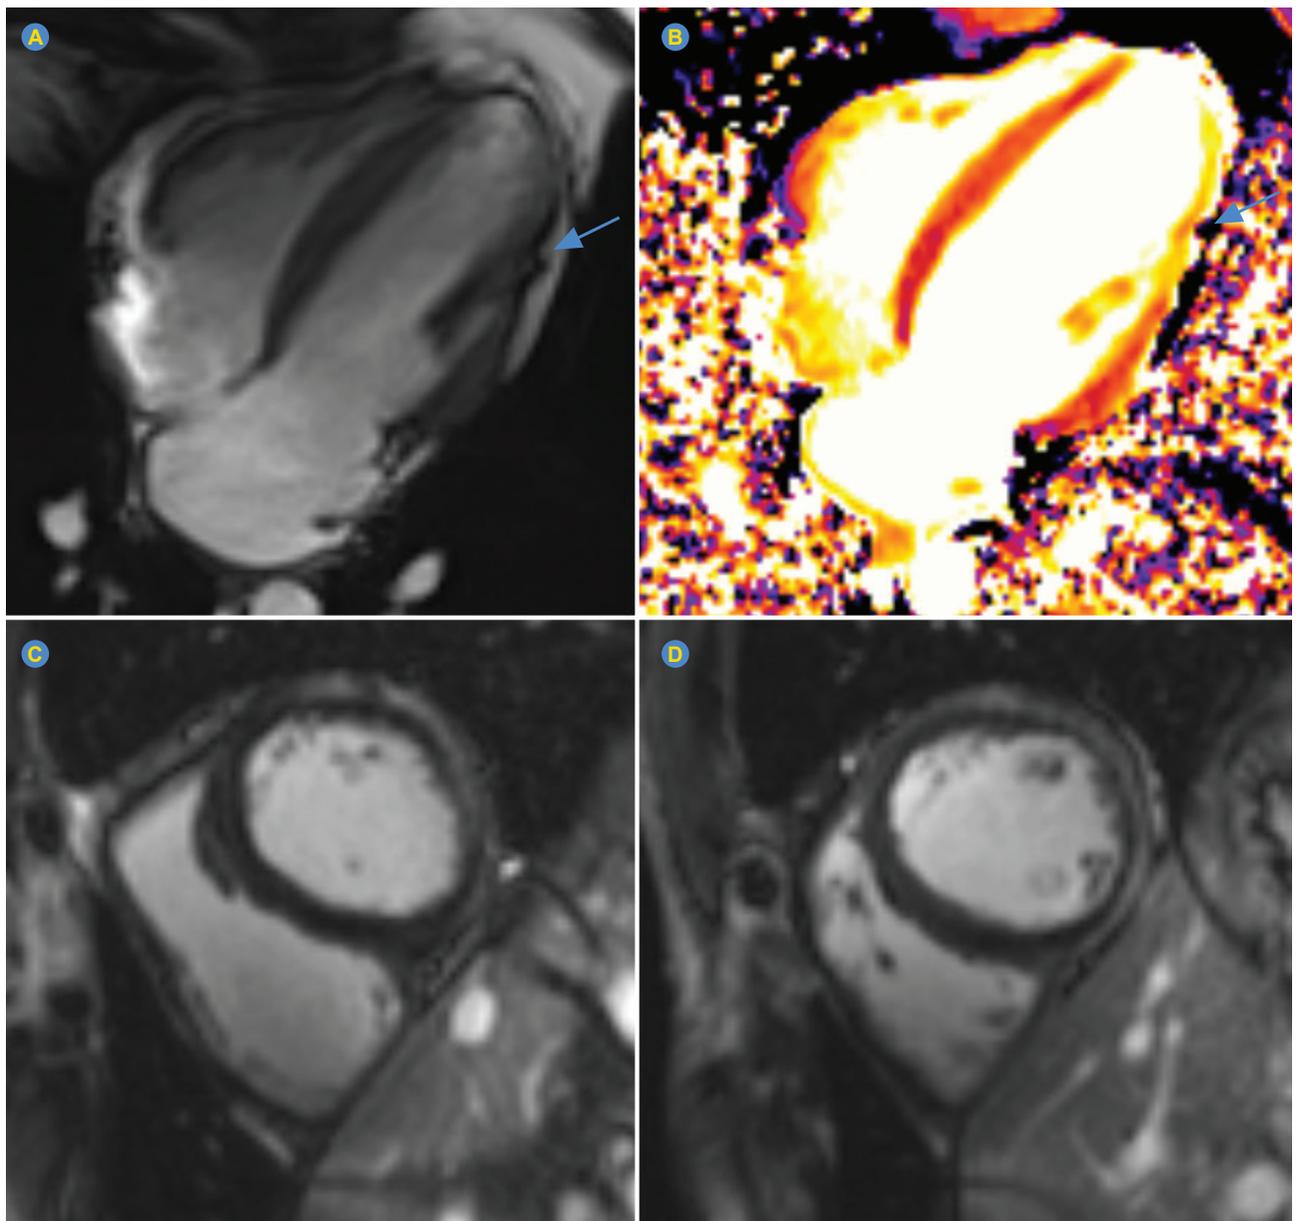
Cardiovascular magnetic resonance imaging showing subepicardial fatty infiltration of the left ventricular lateral wall (arrows) in cine images (A) and native T1 mapping (B); extensive subepicardial late gadolinium enhancement in the anterior, lateral and inferior walls (C and D)
